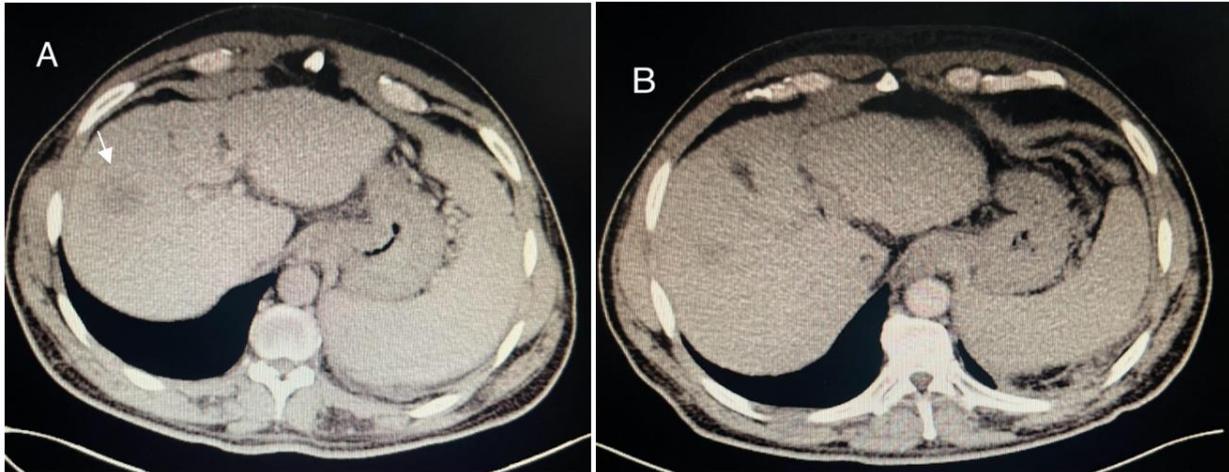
Contrast-enhanced abdominal computed tomography; A- A hypodense lesion of liver measuring 50x41mm straddling segments VI and VIII with signs of early arterial enhancement, consistent with HCC characteristics (white arrow), B: one month after microwave ablation
